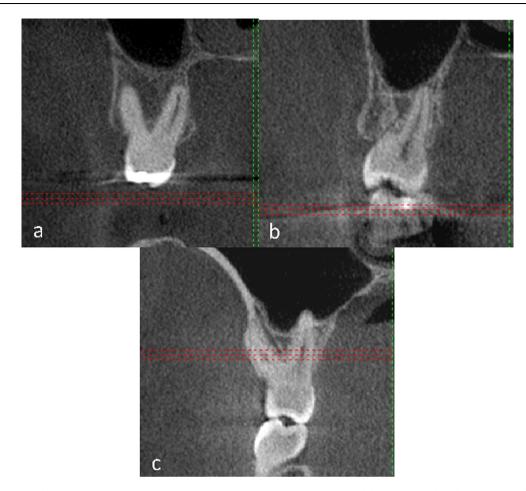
Cropped CBCT coronal cuts, a shows roots with Score 1, b shows root with Score 2 and c shows root with Score 3.
